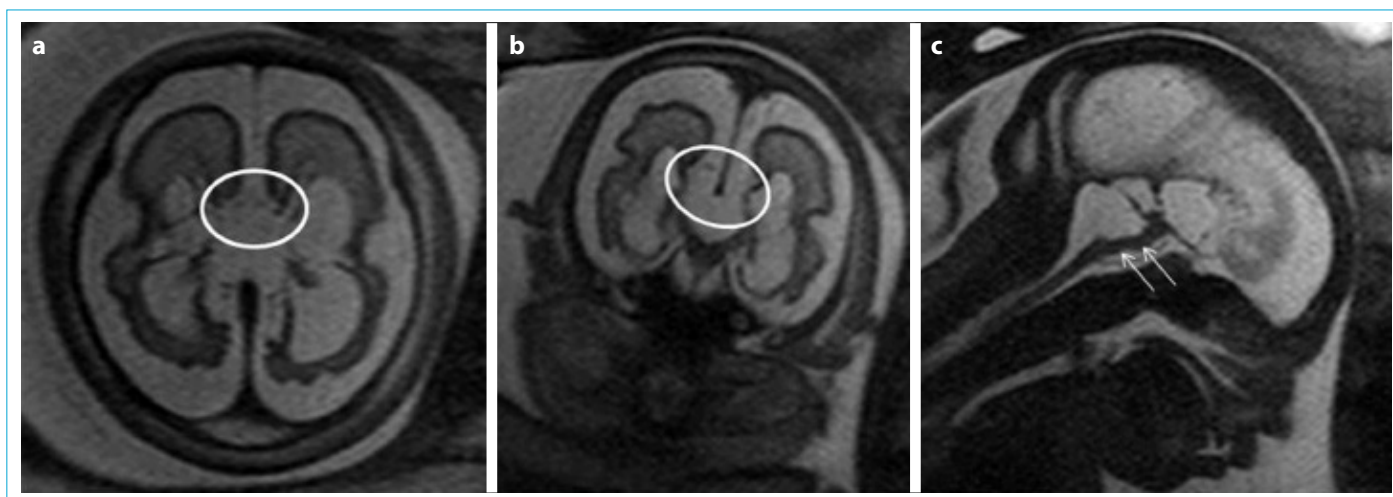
(a-c). Axial (a), coronal (b), and sagittal (c) T2-weighted MRI show total corpus callosum agenesis (circle). In addition, cerebellar tissue is not observed. The brainstem is hypoplastic (thin arrows).
